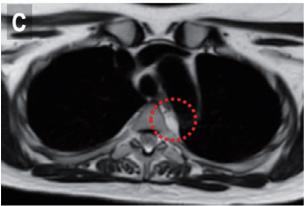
Preoperative images. (A) Plain chest computed tomography revealed a well-defined 14×7 mm paravertebral mass at the level of the left 5th thoracic vertebra in the posterior mediastinum. (B) Chest magnetic resonance imaging (MRI) shows a cystic mass with low signal intensity on T1-weighted images. (C) The cystic mass shows high signal intensity on T2-weighted MRI images.
